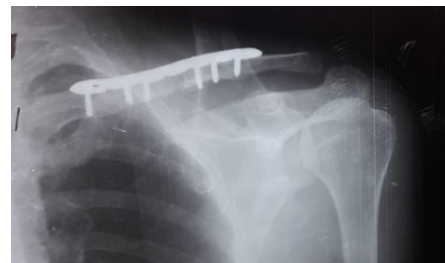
Follow-up xray 3 month
